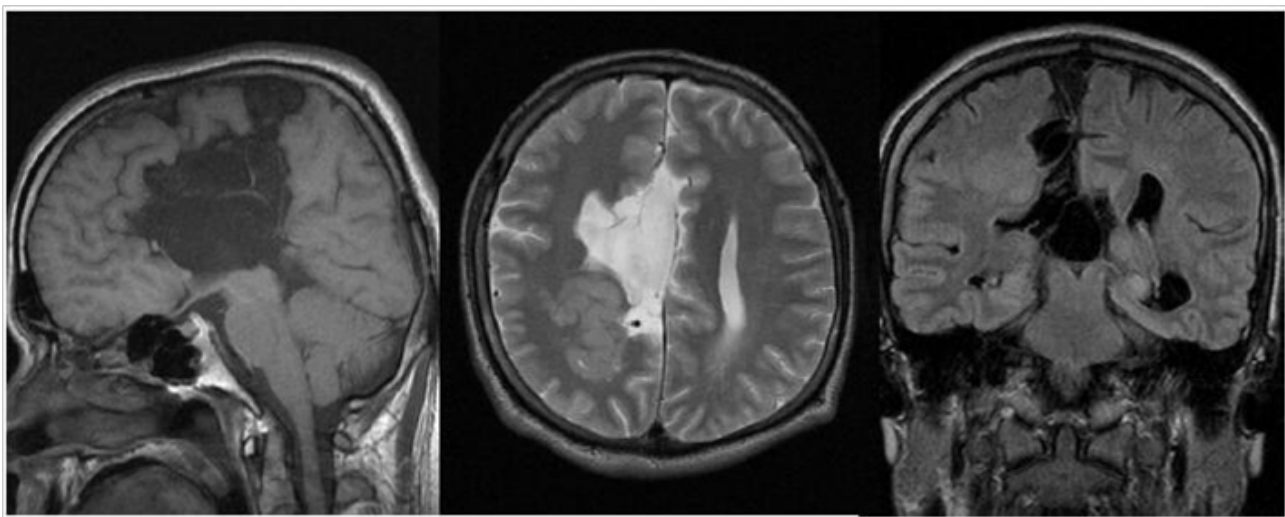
Brain MRI, T1 sagittal(Left), T2 axial(Middle), FLAIR coronal(Right).
